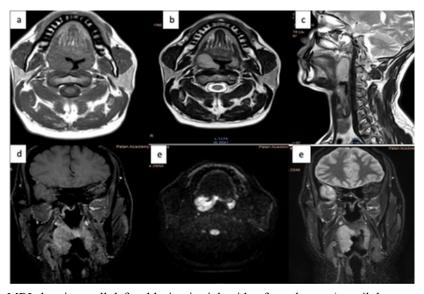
Plain and contrast MRI showing well defined lesion in right side of oropharynx/ tonsil demonstrating T1 isointensity (a), T2 hyperintensity (b,c) with mild diffusion restriction(e). Post contrast study shows mild and homogenous enhancement on post contrast study(d,f)
